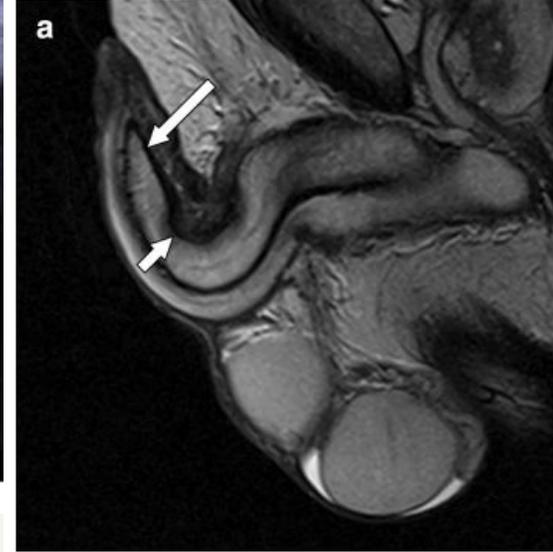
a Sagittal T2-weighted image of the penis demonstrates thickening and irregularity of the tunica albuginea along the dorsum of the penis (short white arrow). The tunica albuginea elsewhere is uniform in thickness and has a smooth appearance (long white arrow). The plaque is located at the penile base, which is a difficult
